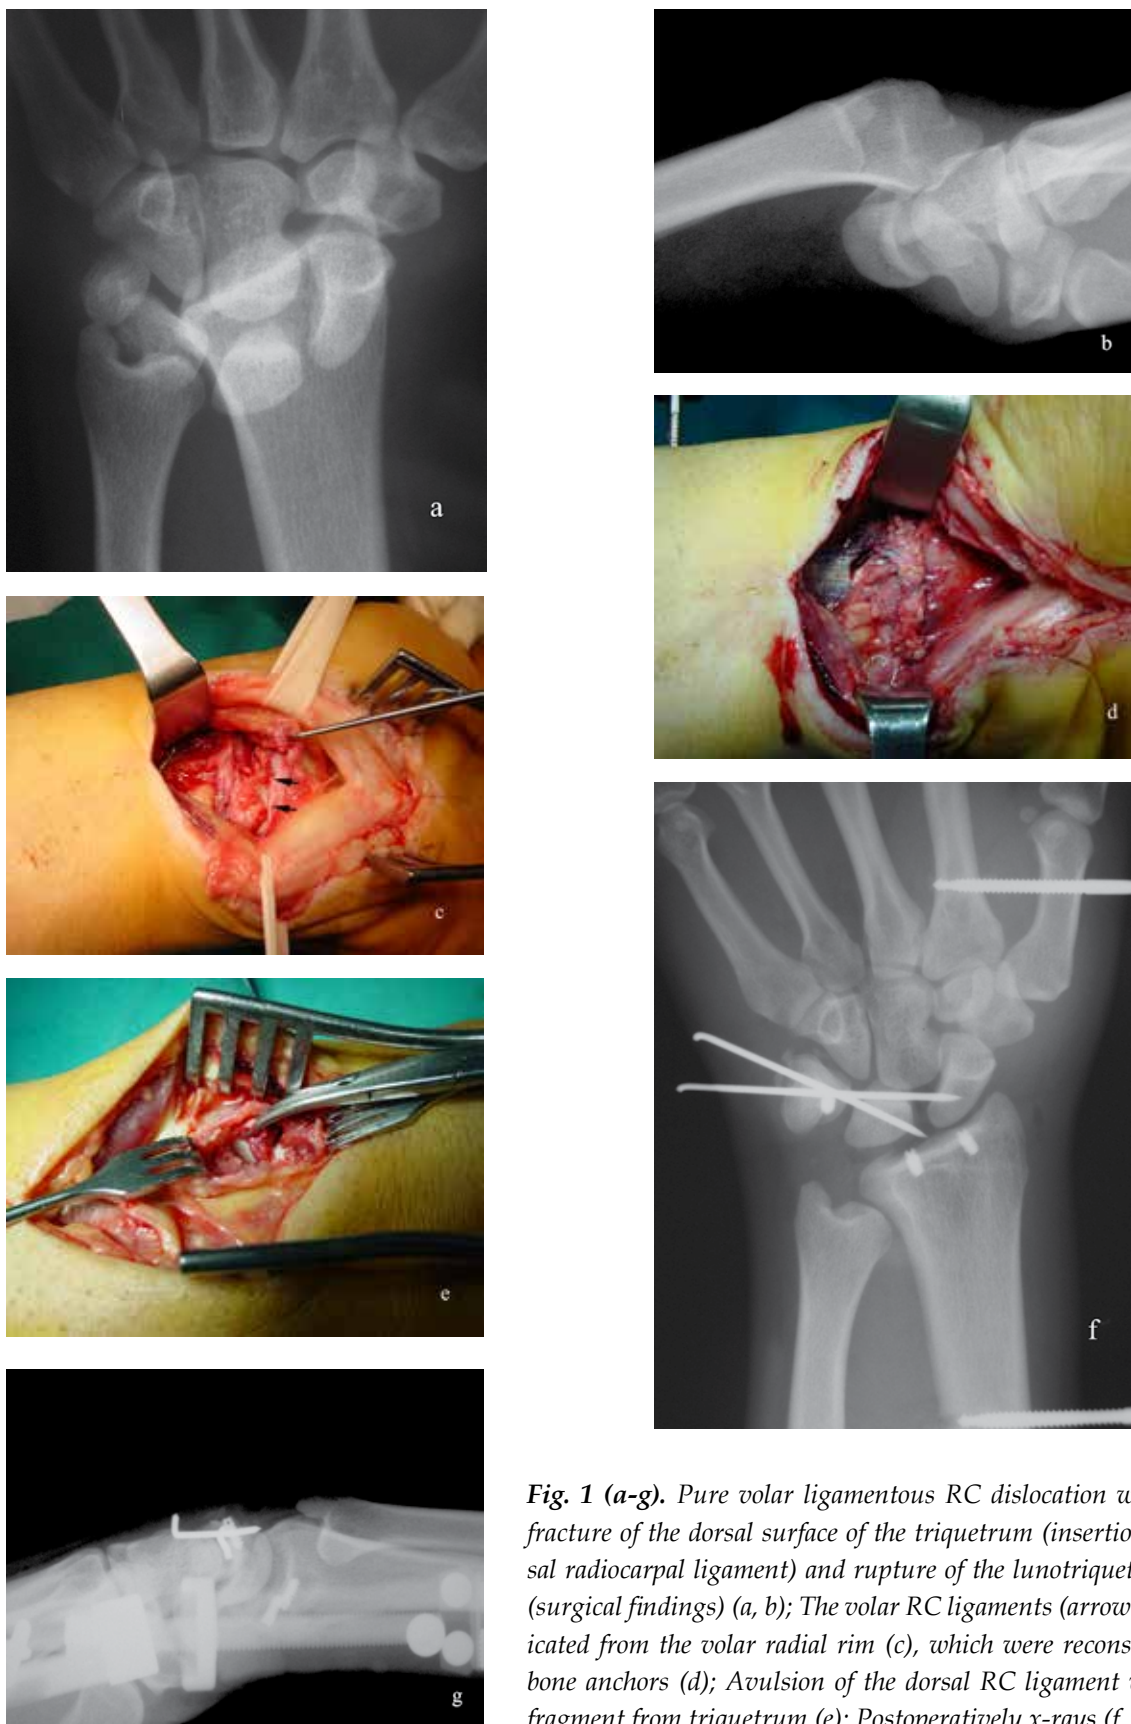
(a-g). Pure volar ligamentous RC dislocation with avulsion fracture of the dorsal surface of the triquetrum (insertion of the dorsal radiocarpal ligament) and rupture of the lunotriquetral ligament (surgical findings) (a, b); The volar RC ligaments (arrows) were eradicated from the volar radial rim (c), which were reconstructed with bone anchors (d); Avulsion of the dorsal RC ligament with osseous fragment from triquetrum (e); Postoperatively x-rays (f, g).
